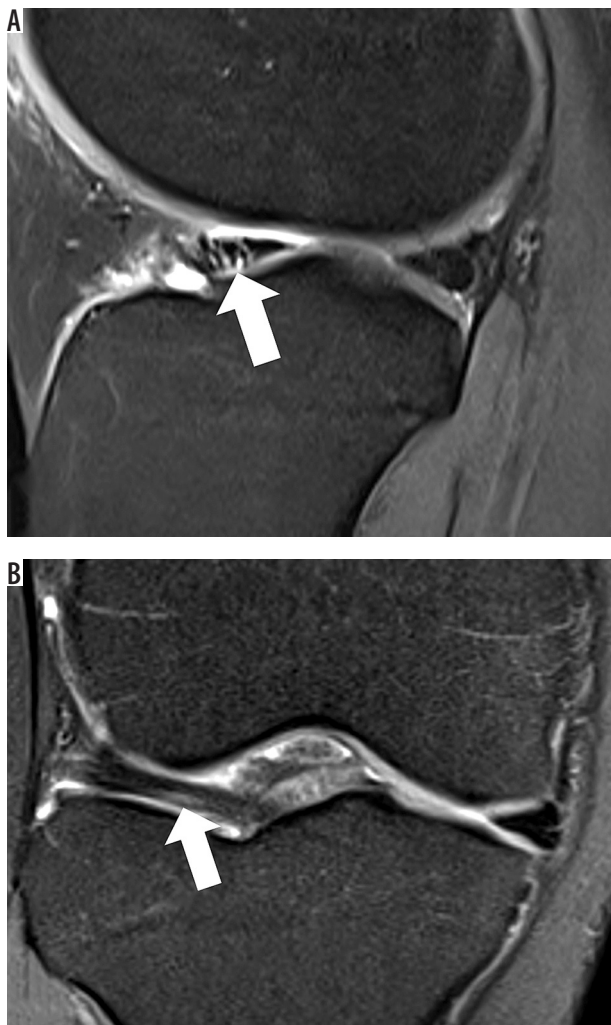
Sagittal proton density fat-suppressed (A) and coronal proton density fat-suppressed (B) magnetic resonance images of the left knee in a 19-year-old male patient with pain demonstrate focal high proton density fat-saturated signal within the anterior horn of the lateral meniscus (arrows). Meniscus morphology is preserved. These findings are most consistent with a pseudotear, particularly given the absence of corresponding lateral joint tenderness on physical examination
